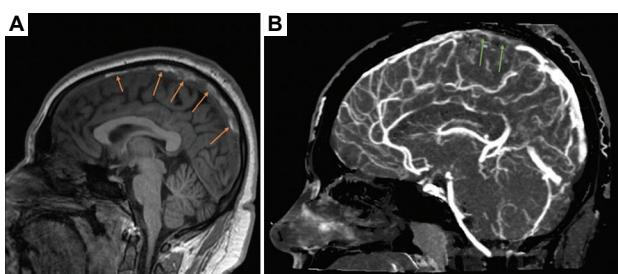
Magnetic resonance (MR) images demonstrating superior sagittal sinus thrombosis. (A) A T1-weighted sequence with a visible thrombus in the superior sagittal sinus. (B) An MR angiogram that confirms the presence of a thrombus by showing filling defects, where the contrast agent does not fill the superior sagittal sinus.
